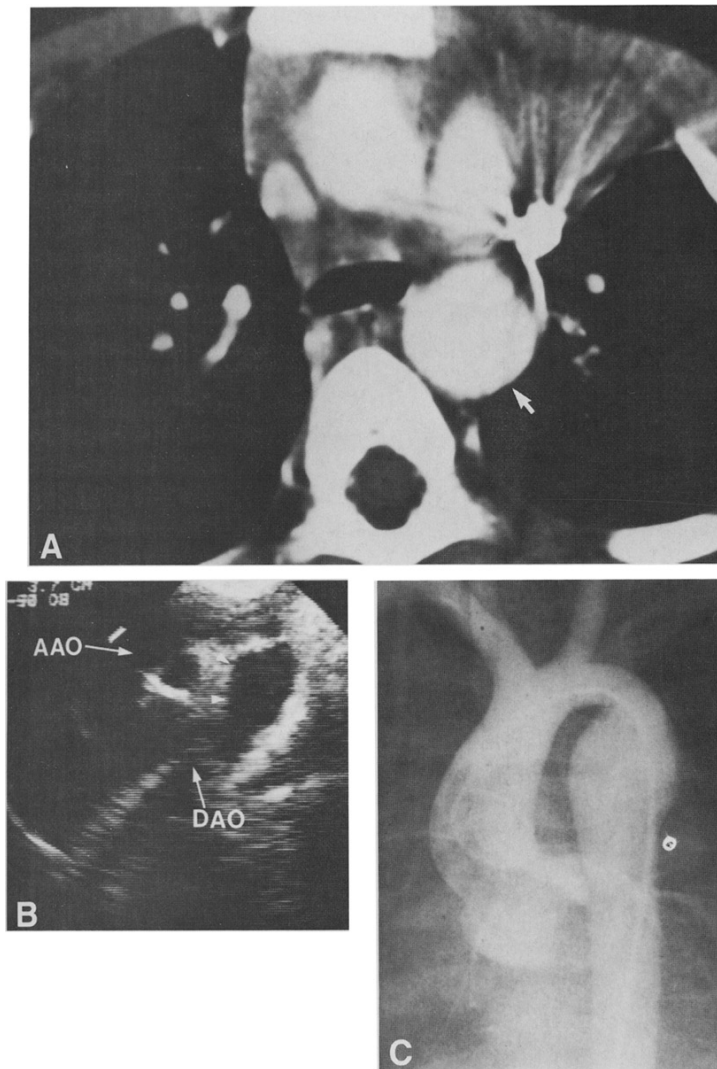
Patient 6. Multiple imaging of an aortic aneurysm, 5 years after Dacron patch aortoplasty repair of coarctation. A, Chest computed tomogram. The cross-sectional view demonstrates aneurysmal aortic dilation at the repair site (arrow). The aortic ratio measured 1.9. B, Two-dimensional echocardiogram. Suprasternal long-axis view of the aortic arch demonstrates marked aneurysmal dilation at the site of repair (arrowheads). The aortic ratio measured 2.3. AAO = ascending aorta; DAO = descending aorta. C, Aortogram demonstrating the fusiform aortic aneurysm at the site of patch aortoplasty. The aortic ratio was 1.6 by angiography.
